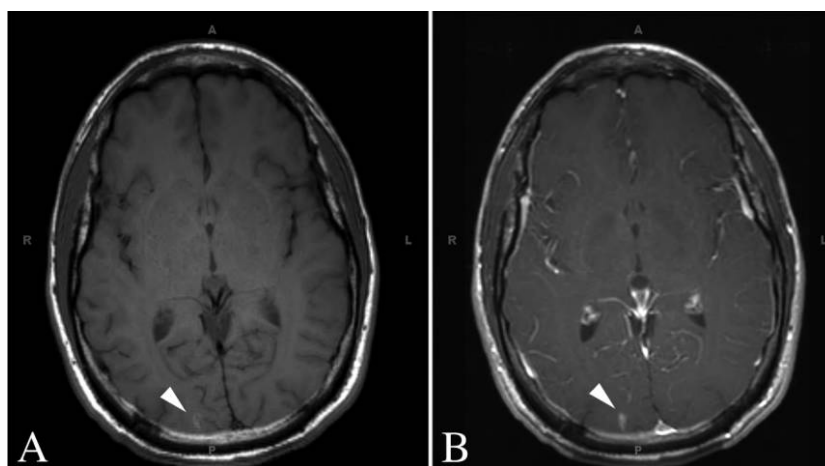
Magnetic resonance imaging (MRI) of the brain of patient 2 showing a 7 × 4 × 2 mm lesion in the right occipital lobe (arrowhead). A, T1-weighted brain MRI. B, Postcontrast enhancement of right occipital lobe lesion.
